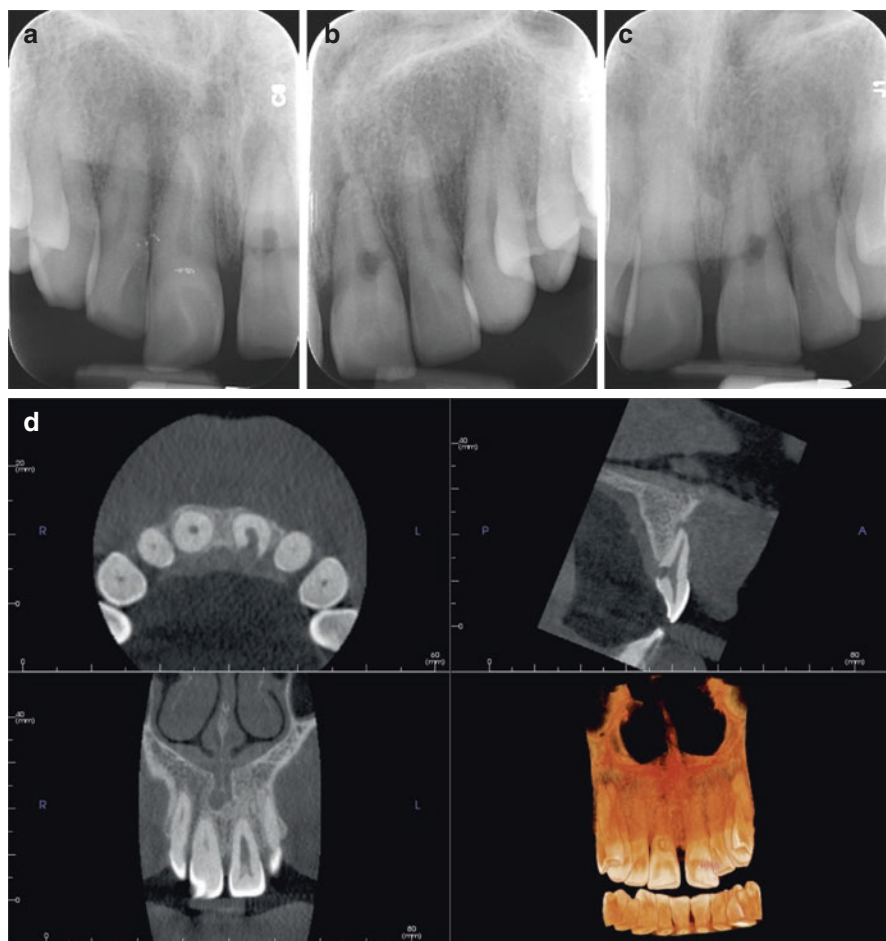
An asymptomatic 44-year-old male presented on referral from his general dentist for evaluation of suspect internal resorption in the maxillary left central incisor. Several angled radiographs were obtained but the true nature and extent of the lesion was uncertain (a–c). The tooth was nonresponsive to pulp sensibility testing and the pulpal diagnosis was necrosis. A CBCT was then obtained (d), and the location and extent of the lesion is now apparent, with presumed initial origin as an external ICR-type lesion that progressed to the pulp. The treatment plan was combined nonsurgical root canal therapy and surgical flap reflection and repair of the palatal defect. Minor orthodontic extrusion of teeth like this is not usually necessary but may be indicated to gain better access for repair
